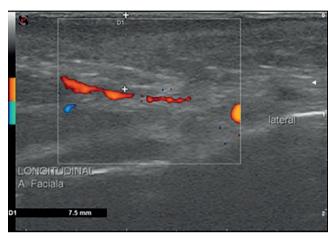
Doppler ultrasonography imaging of the facial artery in the nasolabial fold – longitudinal placement of the ultrasound probe.
